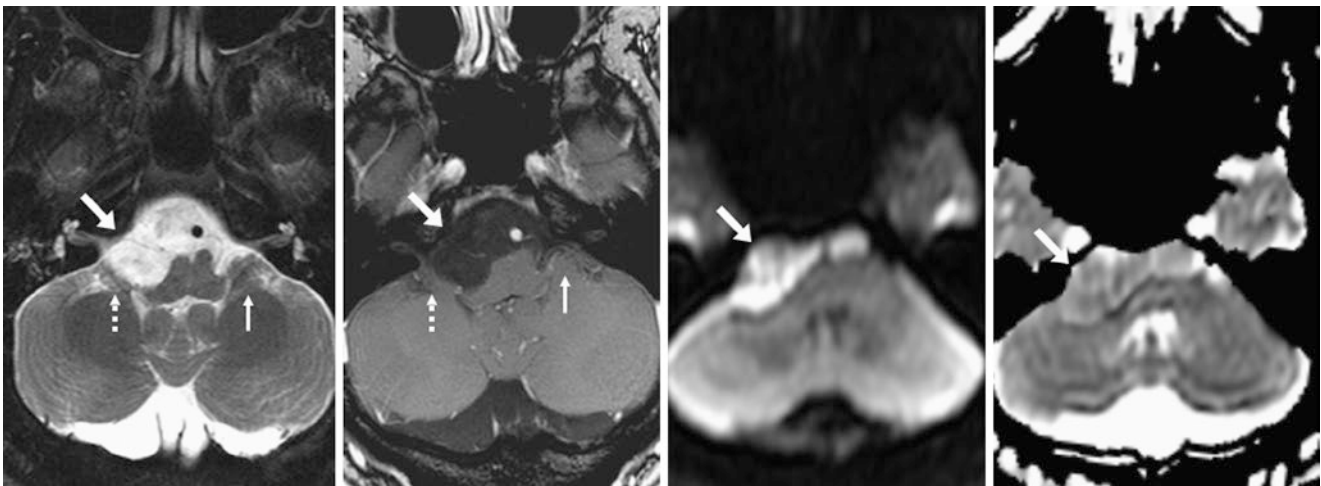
Comparison case of a CPA epidermoid: a 27-year-old patient with headaches and hearing loss had an extra-axial cystic mass (arrows) on a 1.5 T T2WI MRI (left), which did not enhance on postcontrast T1WI (left middle). However, it had reduced diffusivity (bright) relative
